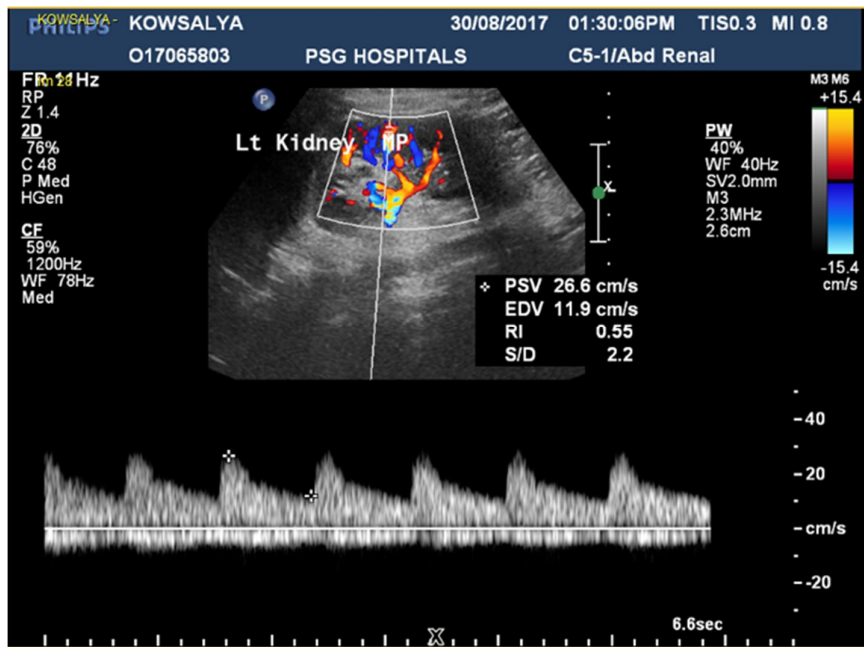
(F) Doppler US demonstrating an RI value of 0.55 in the mid pole of left kidney(unobstructed).
